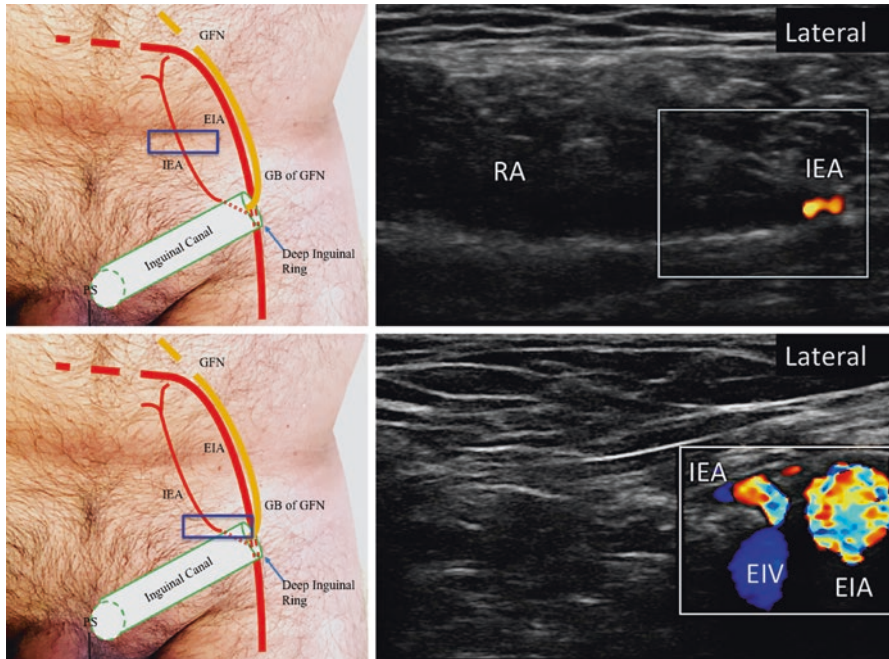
Position of ultrasound probe and the corresponding sonography. GB genital branch of the genitofemoral nerve (GFN), EIA external iliac artery, IEA inferior epigastric artery, PS pubic symphysis, RA rectus abdominis. (Reprinted with permission from Philip Peng Educational Series)
